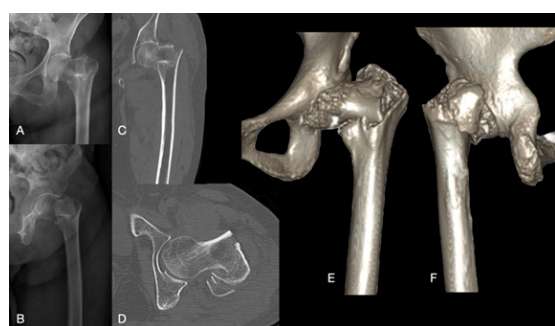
(A and B) Anteroposterior and lateral radiographs of the left femur of an 83-year-old female patient who sustained an unstable intertrochanteric fracture after a fall. (C and D) Coronal and axial CT scan demonstrating fracture displacement and comminution. (E and F) Three-dimensional CT reconstructions highlighting the instability of the intertrochanteric fracture.
